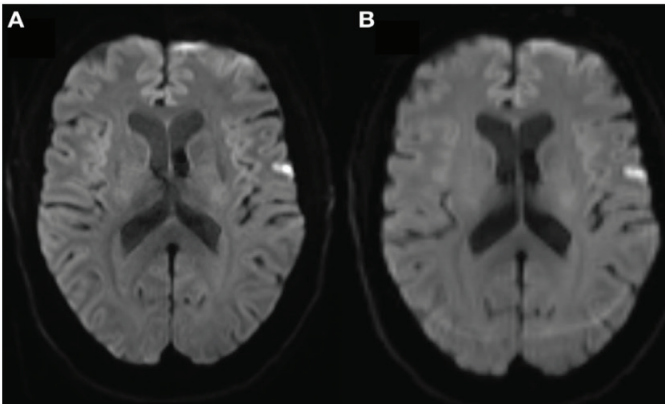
MRI images with, and without movement artifact, demonstrating the need for a movement-free scan to optimize diagnostic quality (Original image demonstrating movement artifact in 68-year-old patient with transient ischaemic attack symptoms lasting two hours, from article: Havsteen et al, 2017).
